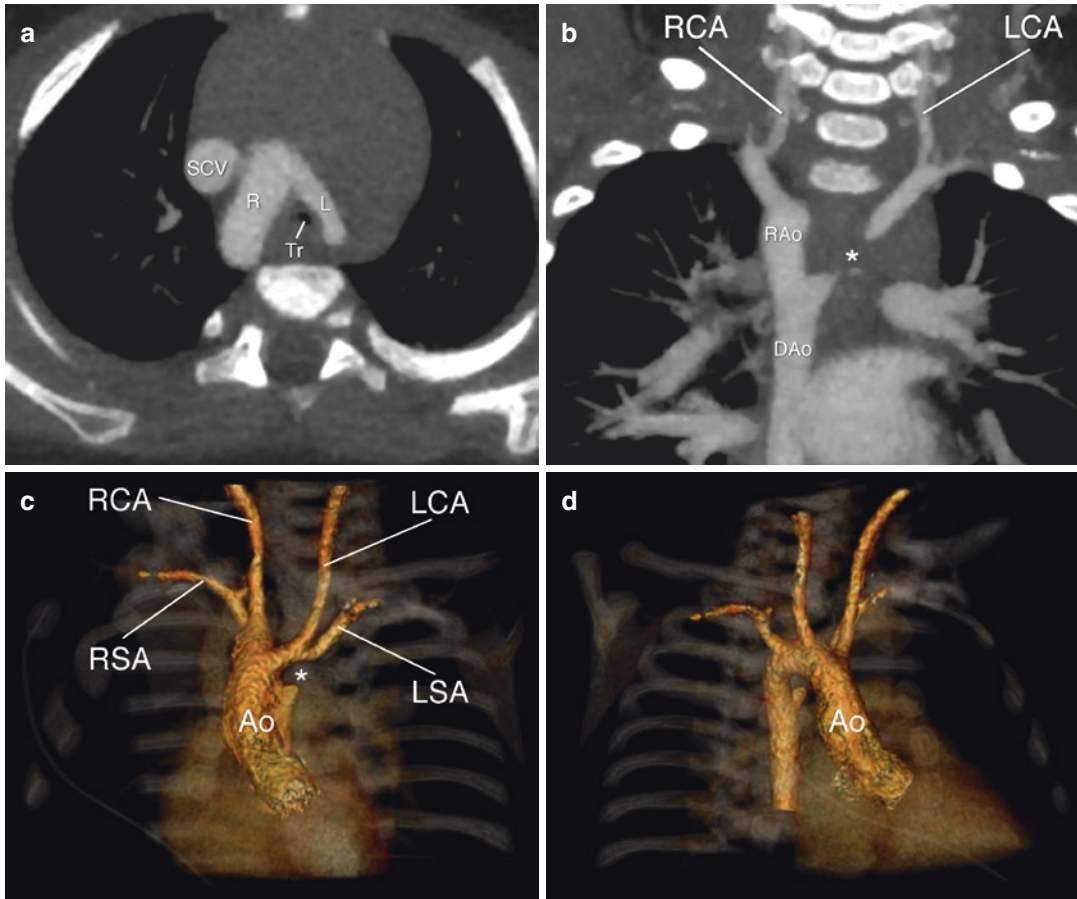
Double-aortic arch with atretic segment. 7-month-old female patient, admitted to the intensive care unit with an upper airway tract infection and a history of multiple severe cyanotic incidents. CT angiography showing complete vascular ring: Double-aortic arch with large right arch and small left arch causing tracheal narrowing (a). An atretic segment (*, fibrous strand, confirmed at surgery) is connecting the left arch to the descending aorta (b). Panels (c) and (d): volume-rendered depictions of the double-aortic arch with symmetric branching of the arch vessels causing the typical four vessel sign. *Ao* aorta, *DAa*
